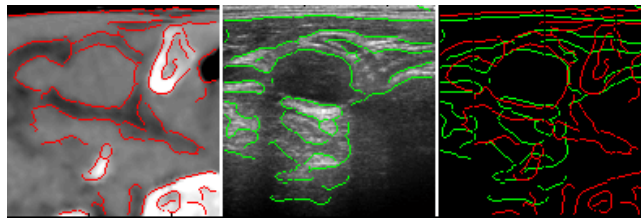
Registered image pair and edge detection result (red=CT, green=US)
